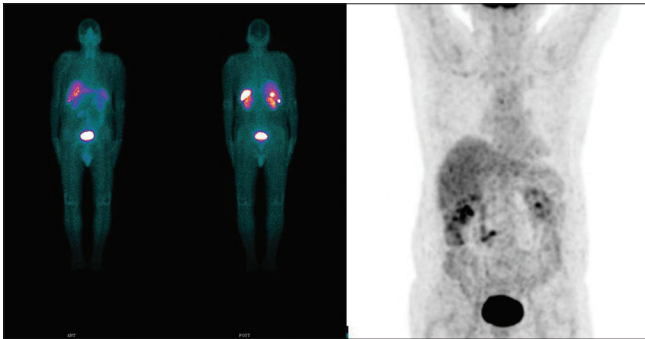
A 65-year-old male diagnosed to have rectal neuroendocrine tumor (MIB-8–10%, i.e. Grade 2 tumor); discordance was observed between (99m) Tc-hydrazinonicotinyl-Tyr(3)-octreotide (left panel, which is avidly concentrated in the hepatic metastatic lesions) and FDG-PET/CT (right panel, MIP view; demonstrating no uptake in metastatic lesions)
